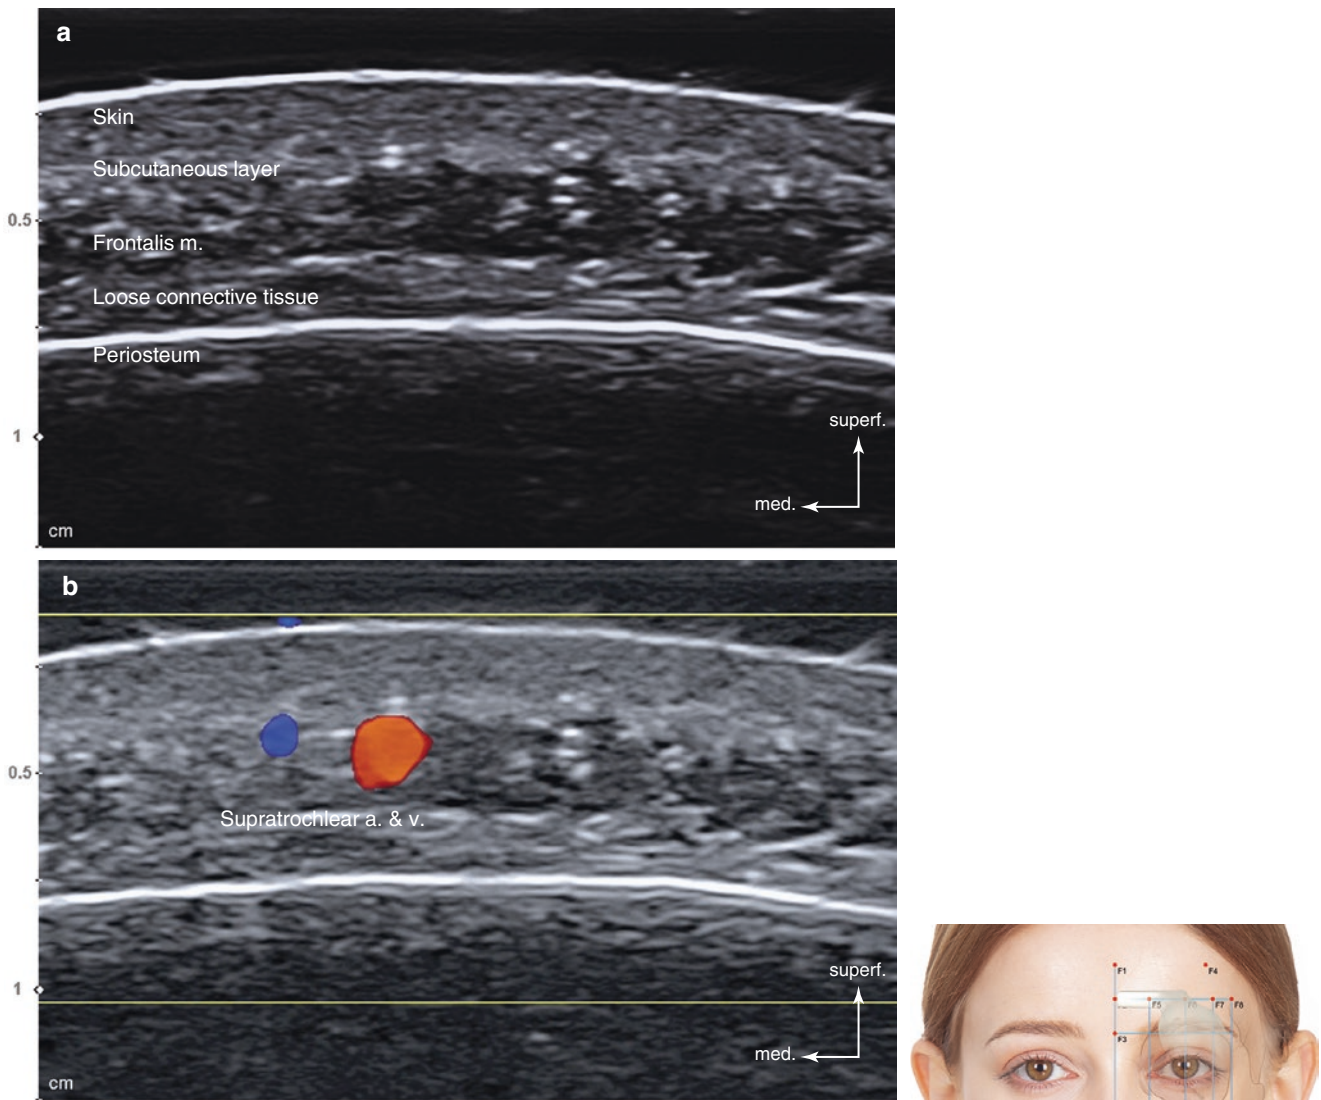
Ultrasonography of the intersection point of TL1 and PL1 (F5). (a) B mode (transverse view, 15 MHz by linear transducer), (b) Doppler mode (transverse view, 15 MHz by linear transducer), and (c)
